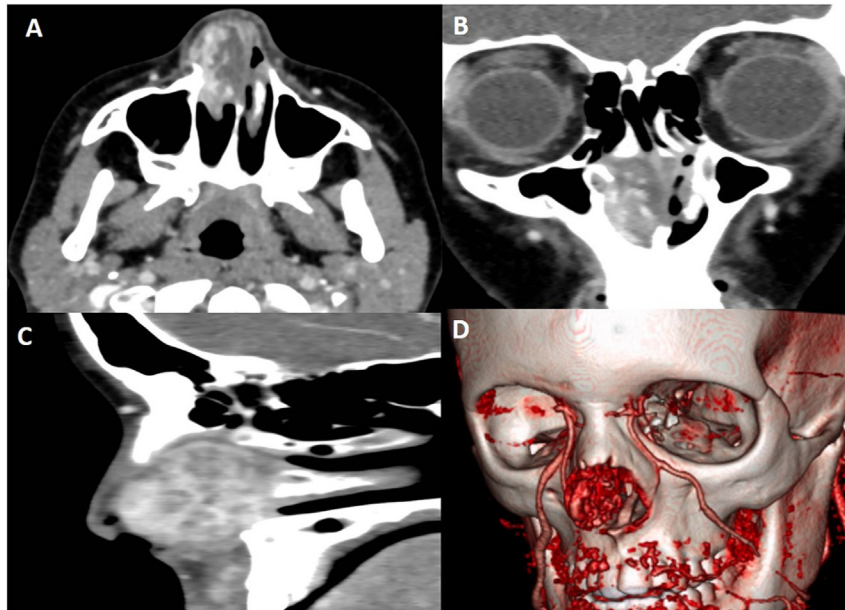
Case 1. Contrast enhanced computed tomography (CT). Axial (A), coronal (B) and sagittal (C) sections, and 3D reconstruction of vascular structures (D).
